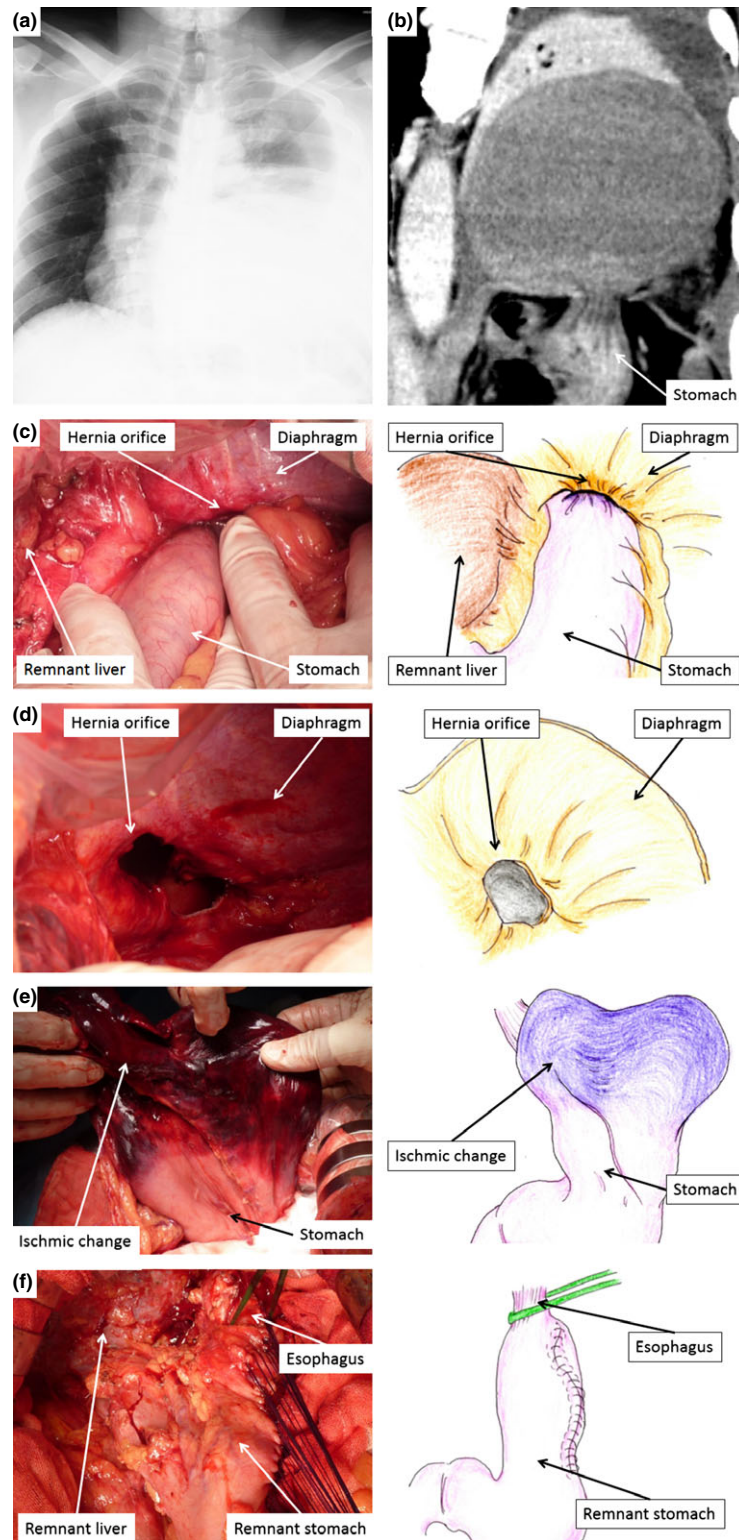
a) A chest radiograph showed a huge mass in the left lower lung field and that the heart and trachea were shifted to right side. b) A computed tomography scan on coronal reformation revealed a left-sided diaphragmatic hernia with partial gastric obstruction. c) The stomach and greater omentum were protruded into the left hemi-diaphragmatic defect. d) The hernia orifice was irregular with margins that were 4 cm × 3 cm in size. e) The greater curvature of the stomach and the greater omentum revealed partial ischemic change. f) A partial resection of the greater curvature of the stomach was performed.
